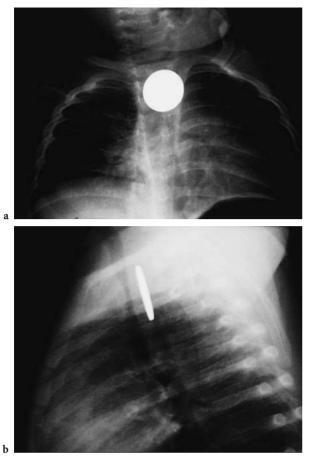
Chronically impacted coin. Frontal (a) and lateral (b) chest radiographs with an impacted coin and inflammatory narrowing of the adjacent airway. The space between the trachea and the esophagus is thickened, evidence of chronic inflammatory change
